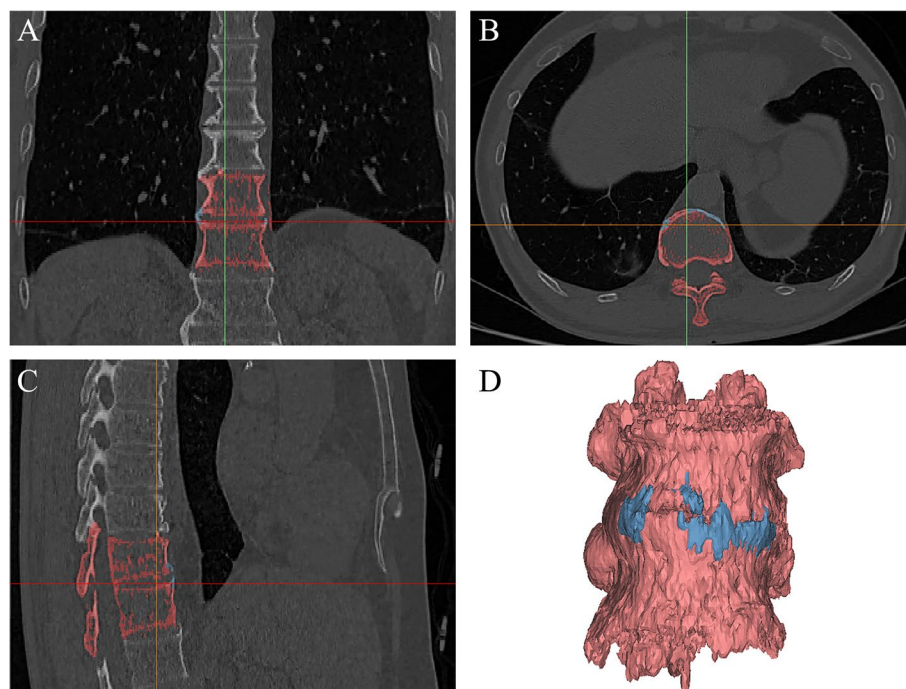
Thoracic CT and 3D reconstruction of a 53-year-old male patient with AS. (ABC) Syndesmophytes in T11-T12 were marked in blue in coronal, axial, sagittal, respectively. Vertebrae were marked in red. D The 3D reconstruction of syndesmophytes were automatically made in Mimics software according to the marked blue area in ABC
